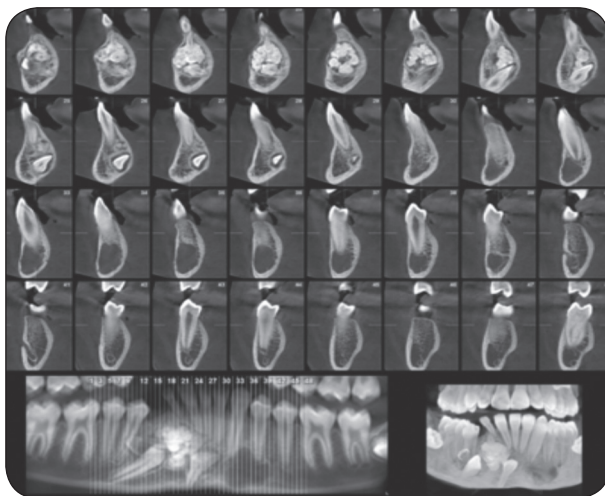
Preoperative CBCT of GPI
